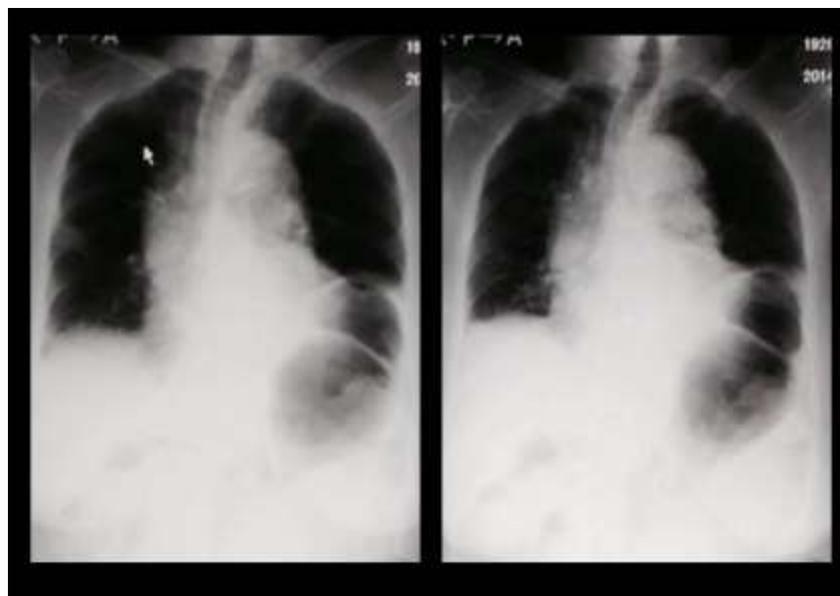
A chest roentgenogram at the exhalation-inspiration phase. The level of the left diaphragm did not change (left; exhalation, right; inspiration)
